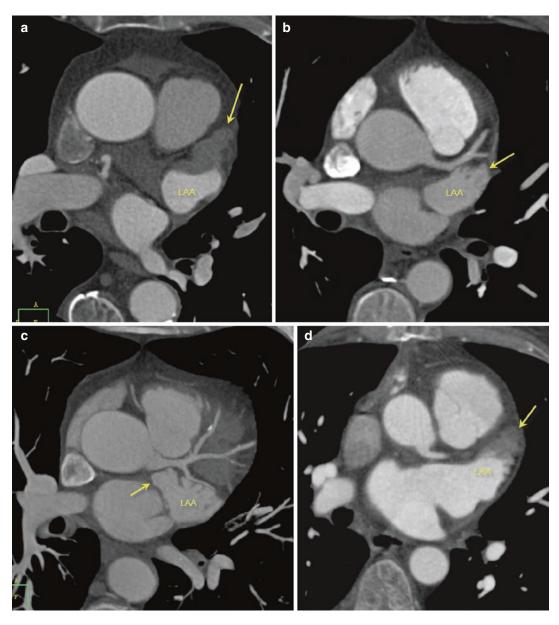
(a) Axial. Discrete low density in the left atrial appendage (LAA) confirmed by transesophageal echocardiography (TEE) to represent a thrombus (*arrow*). (b) Axial. Normal typical triangular appearance of the LAA (*arrow*) in a different patient. (c) Axial: Anatomic variant of the LAA
